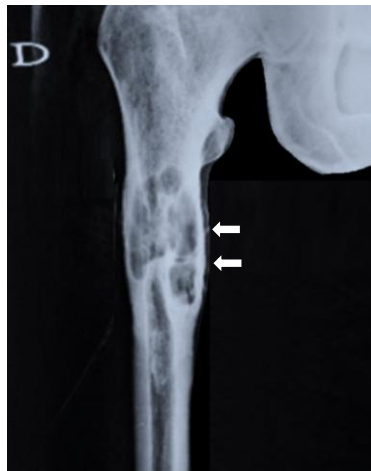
Plain roentgenogram showing proximal right femur cystic pseudo tumoral mass deforming the cortex.
